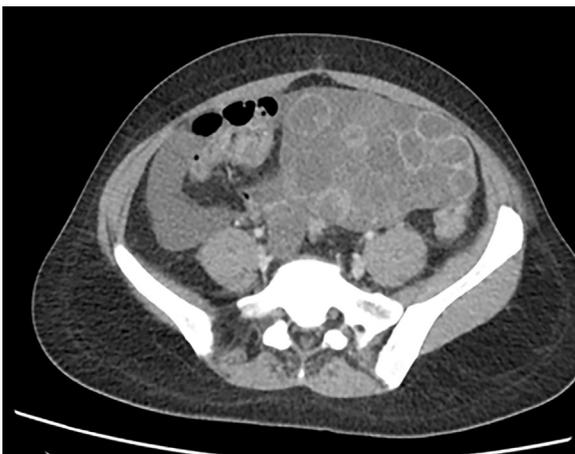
Axial computed tomography scan reveals an enlarged left ovary with multiple follicles. The enhancing walls of the follicles are visible.
